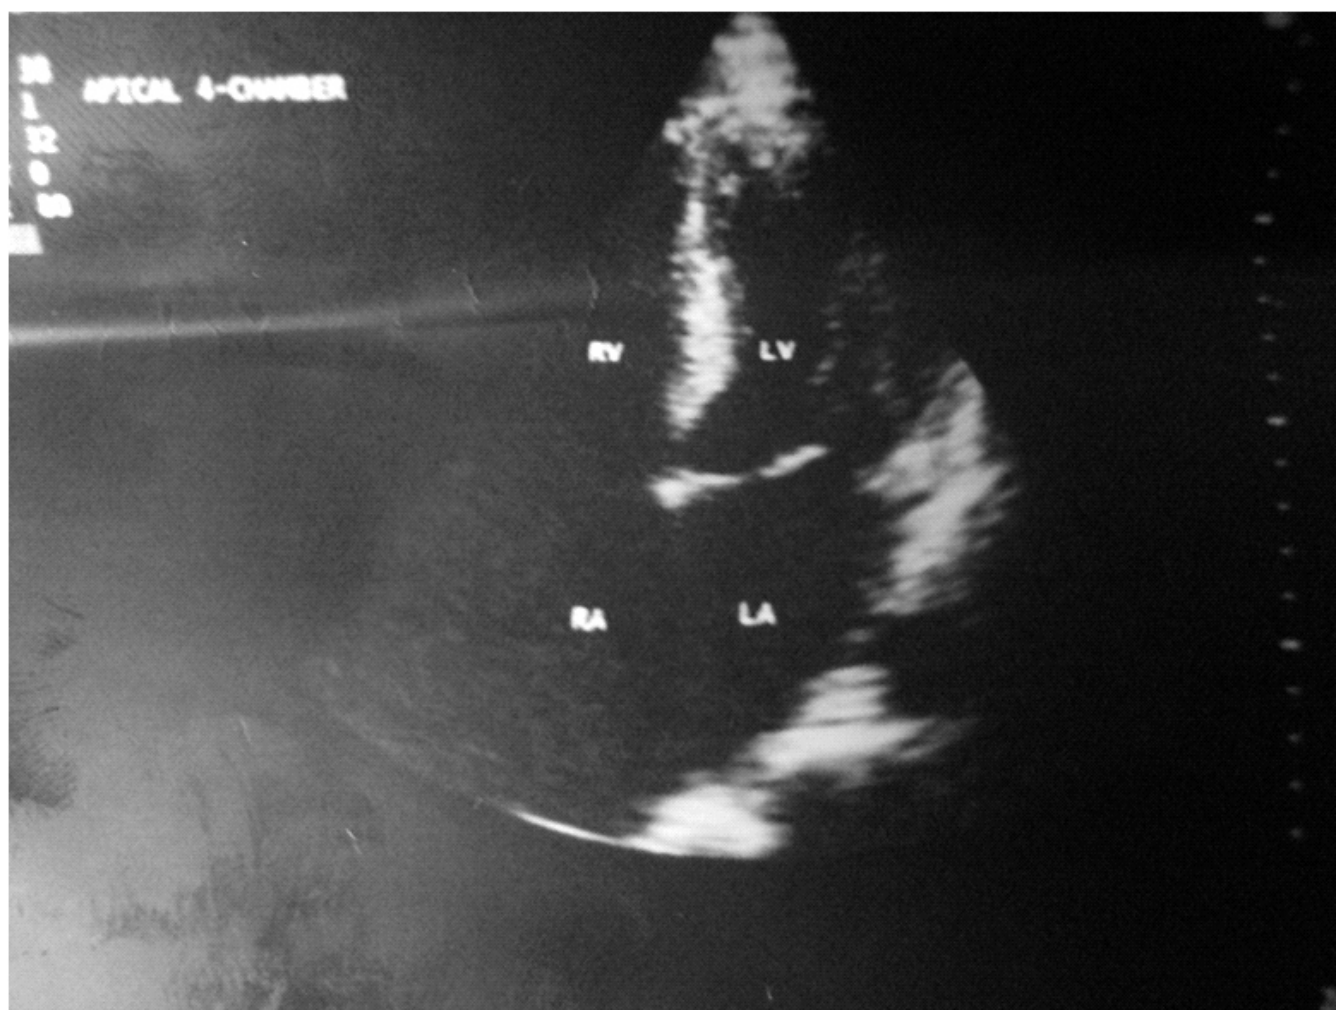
2D Echocardiography-apical 4 chamber view of the patient. Arrow showing Hypertrophied Interventricular Septum and Left Ventricular Free wall.
